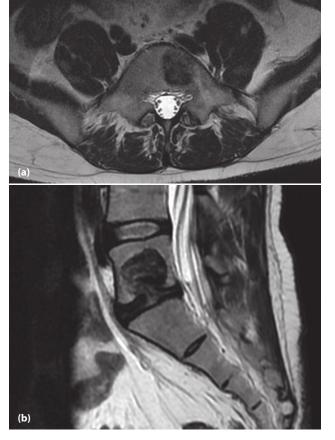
Magnetic resonance (MR) images of lumbar spine. (a) On a transverse T2-weighted image, atypical lesion with intermediate signal intensity. (b) On a sagittal image, the lesion appears in the body of L5 vertebra, with focal intermediate signal intensity foci.
